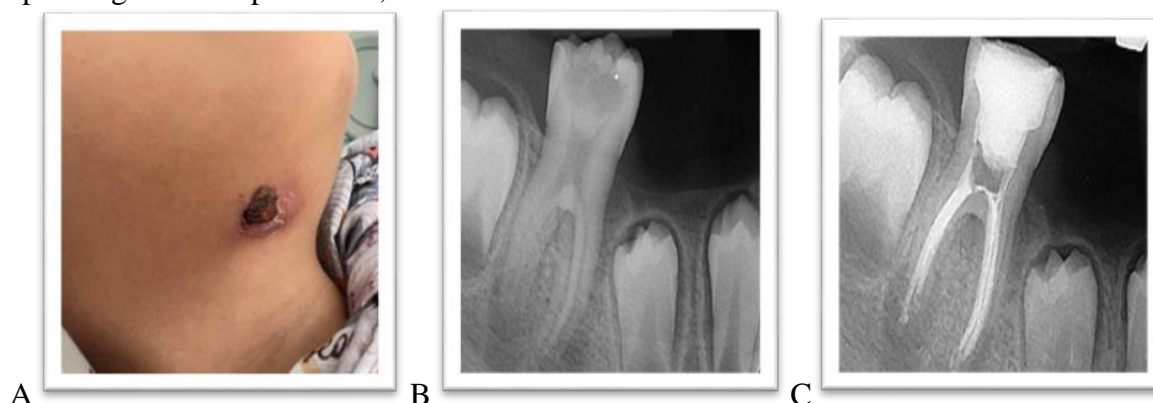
(A) Clinical appearance of the draining cutaneous lesion with mild erythema. (B) PA radiograph of the right mandibular first molar showing deep occlusal caries and a radiolucent lesion in the PA area. (C) PA radiograph after obturation.
